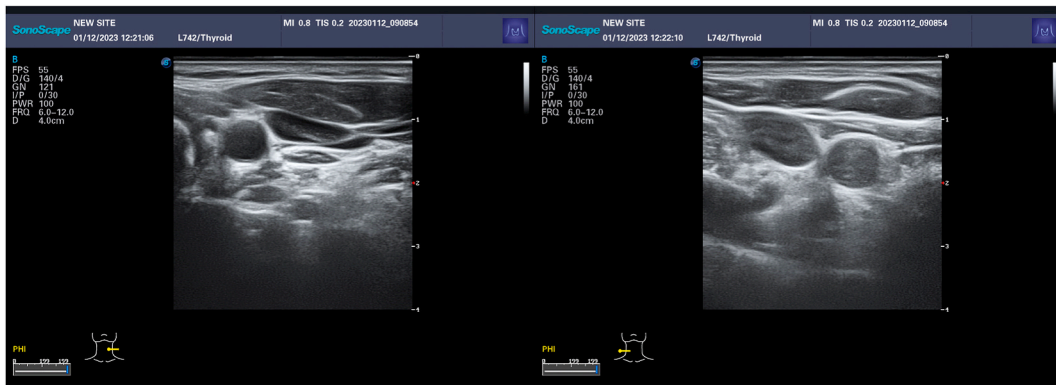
Cervical lymph node color ultrasound after treatment. Bilateral neck scan: no apparent abnormal lymph node echo, CDFI: no abnormal blood flow signal.
